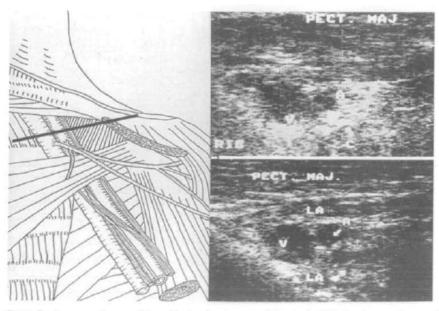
Section across the apex of the axilla showing the artery (A) and vein (V) before (upper ultrasound picture) and after (lower ultrasound picture) the injection of 30 ml of 1.5% lignocaine solution in water (LA). The artery and vein are better defined after LA injection, but are not separated. PECT.MAJ. = pectoralis major.
